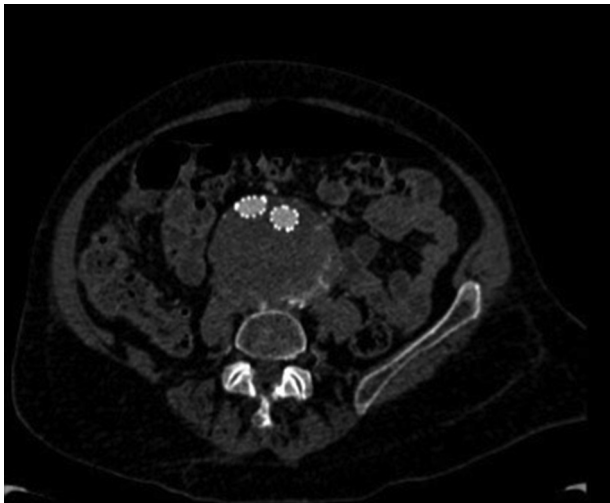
Axial computed tomography (CT) sequence showing a type II endoleak from the posterior lumbar artery.
